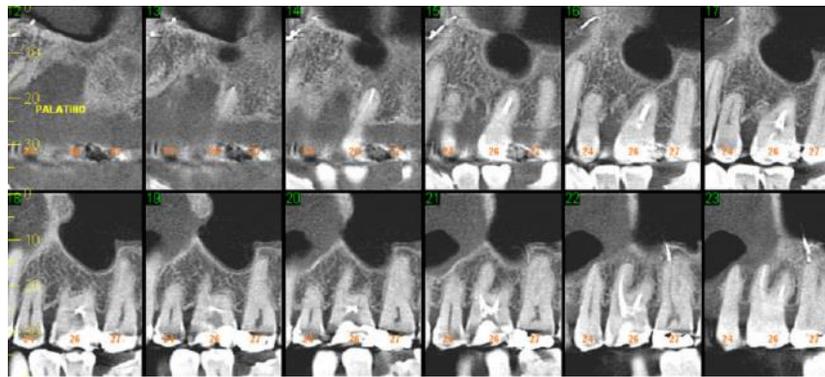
CBCT parasagittal view of the surgical ciliated cyst. Well-circumscribed round-shaped unilocular hypodense area, observed inside the maxillary bone, communicating with the maxillary sinus, in a patient with a history of orthognathic surgery.
